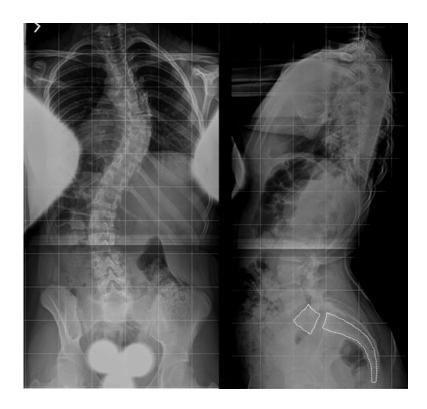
AP and lateral radiograph showing a grade 1 L5–S1 spondylo-listhesis and a 55° idiopathic scoliosis
